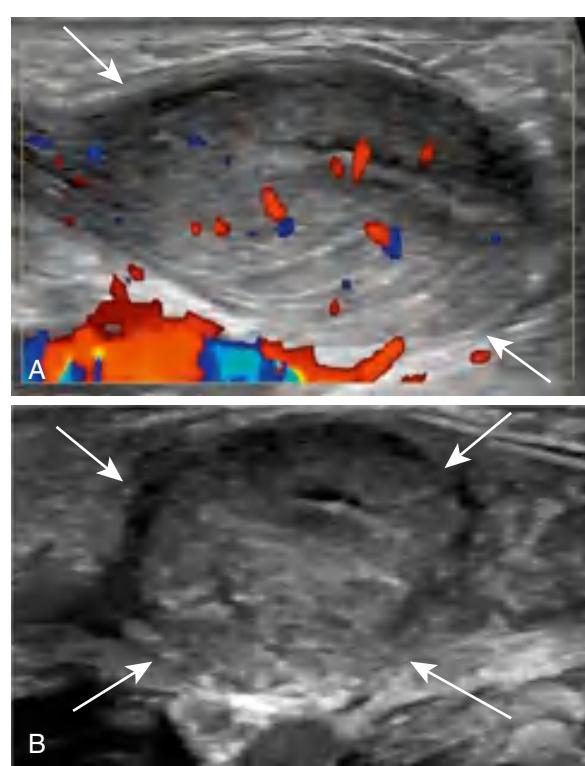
Sonographic image of the symptomatic left neck in a 3-wk-old neonate with fibromatosis colli of the left sternocleidomastoid muscle. A, Longitudinal image of the sternocleidomastoid muscle showing enlargement with a fusiform configuration and masslike focus within the expanded segment of the muscle (arrows). The echotexture of the mass is mildly heterogeneous and echogenic compared with the normal muscle on the contralateral side. Color flow is preserved within the mass. B, The mass has a more rounded configuration on the transverse ultrasound image (arrows). (From Baik G, Blask A, Reilly BK. Unilateral neck mass in a neonate. J Pediatr. 2018;202:329, Fig. 2.)
